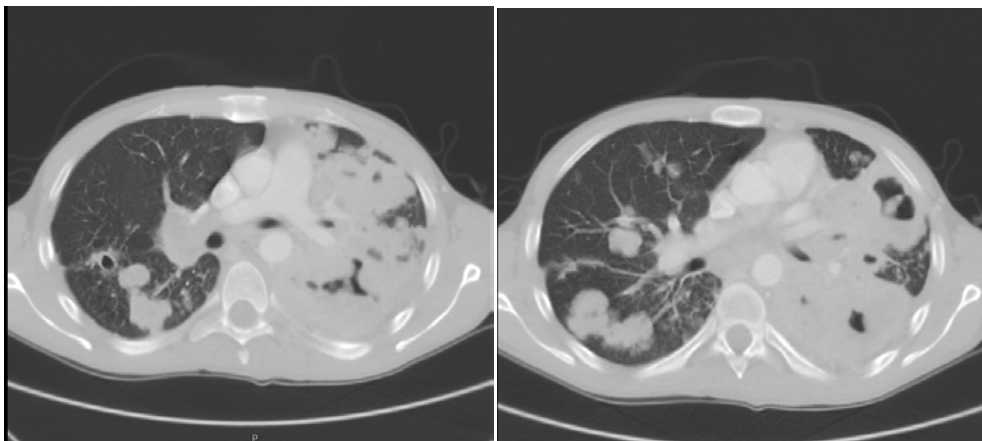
1B. Chest CT - multiple cavitory nodular opacities with near complete opacification of the left
